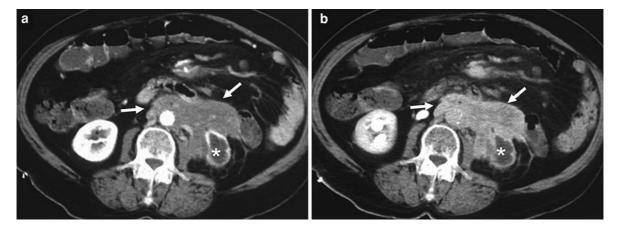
Axial contrast-enhanced multidetector-row CT images during portal-venous (a) and equilibrium (b) phases of a patient with retroperitoneal fibrosis showing a soft-tissue
